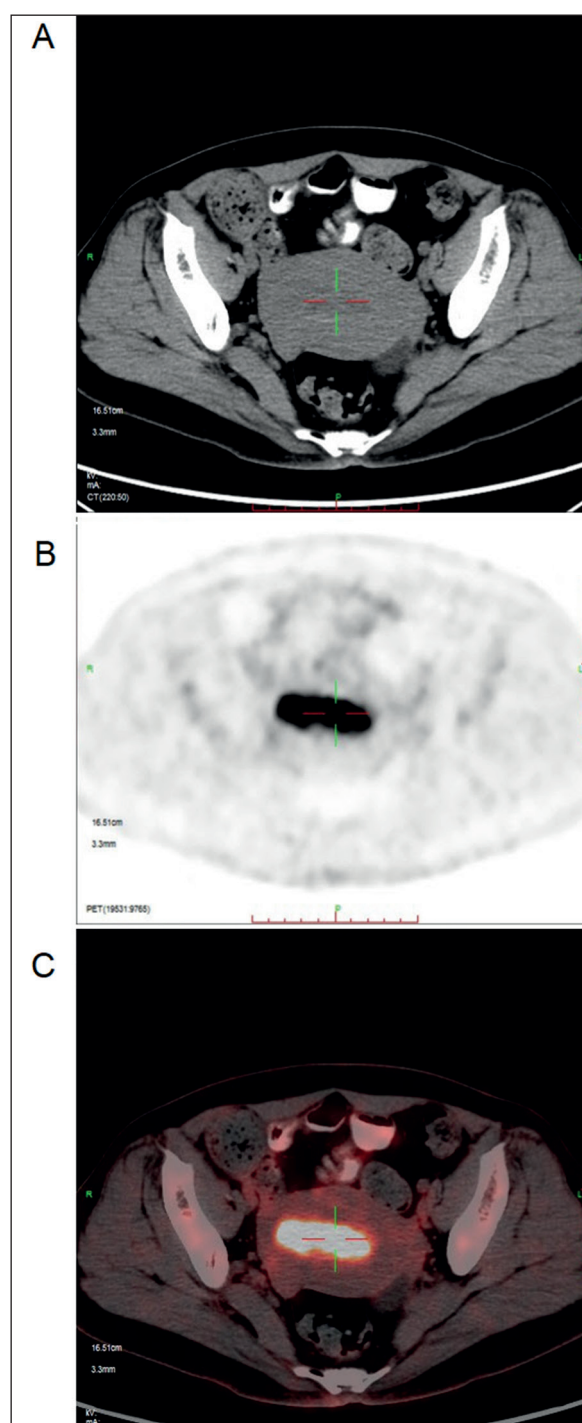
^{18}F -FDG PET/CT image of endometrial cancer. (A): CT Image of Primary Lesions of Endometrial Cancer; (B): PET Image of Primary Lesions of Endometrial Cancer; (C): PET/CT Fusion Image, there was a lesion with increased radiation uptake in the uterine cavity, with SUVmax of 15.31, MTV of 8.12 cm and TLG of 78.63 g.
